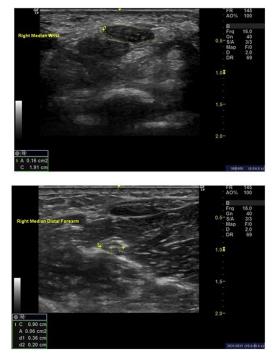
Ultrasound examination of the median nerve at the wrist. (*Top*) Median nerve at the wrist. Enlarged median cross-sectional area (CSA) of 16 mm² at the wrist. (*Bottom*) Median nerve in forearm (CSA 6 mm²). (*Courtesy of* Katalin Scherer, MD.)
